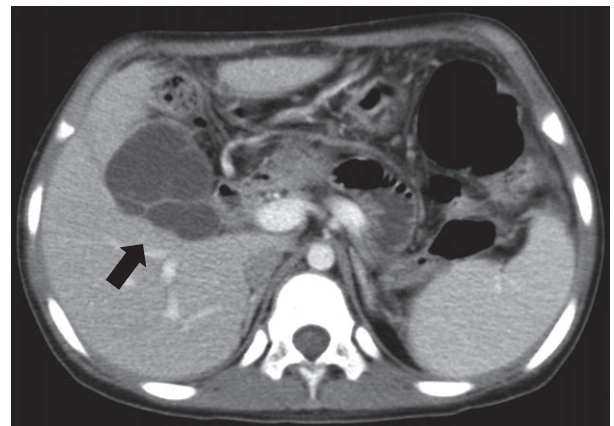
The winding bile duct with partition walls can be seen on computed tomography imaging (arrow).
